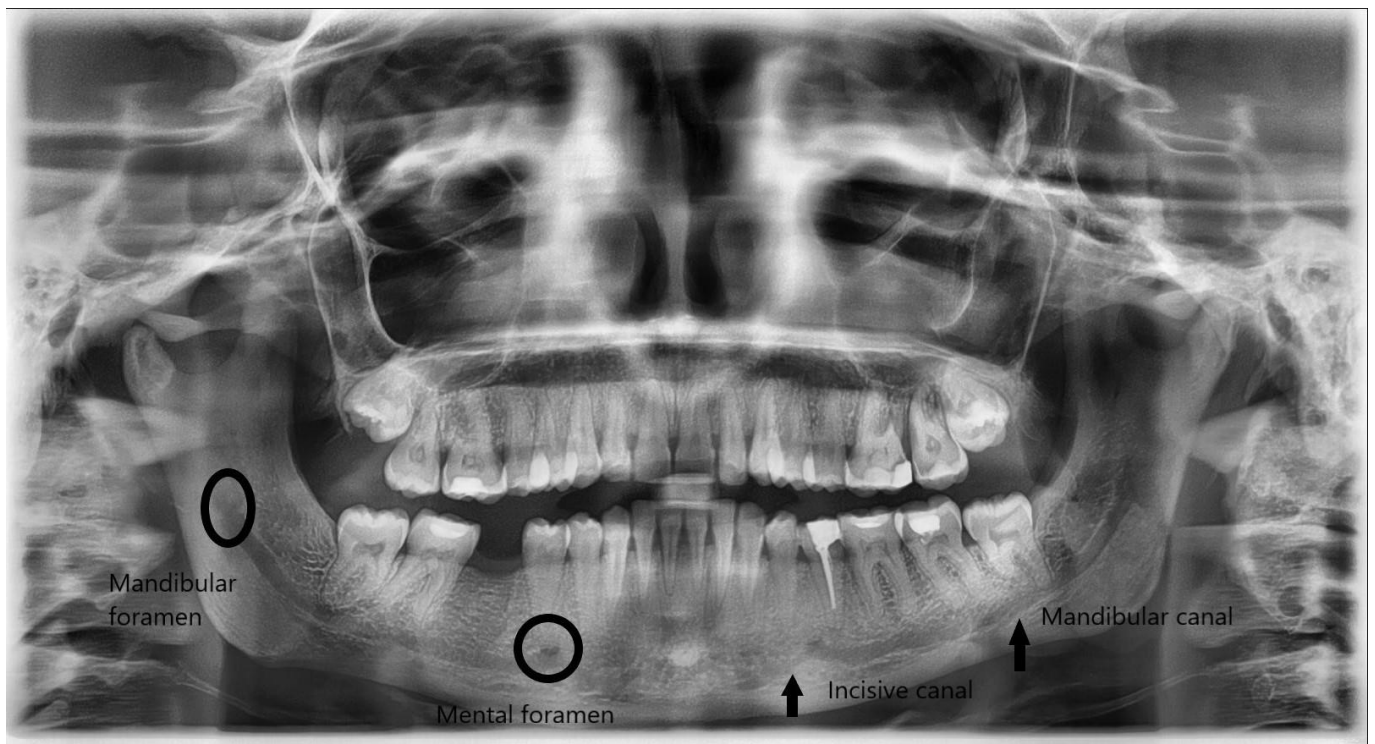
Assessed anatomical landmarks on panoramic radiograph
